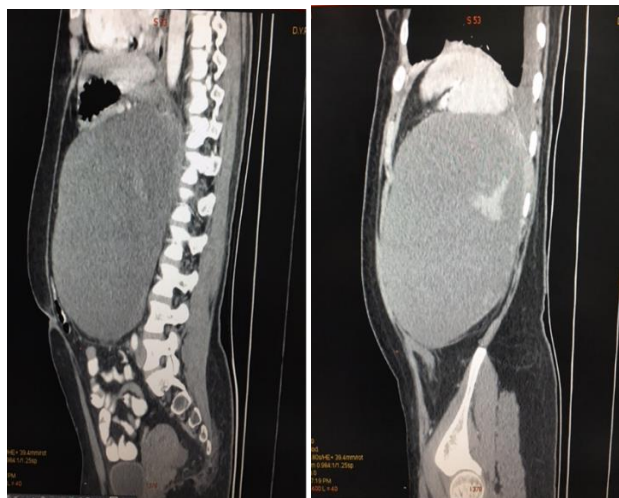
Abdominal computed tomography showed a large well-defined lesion.
